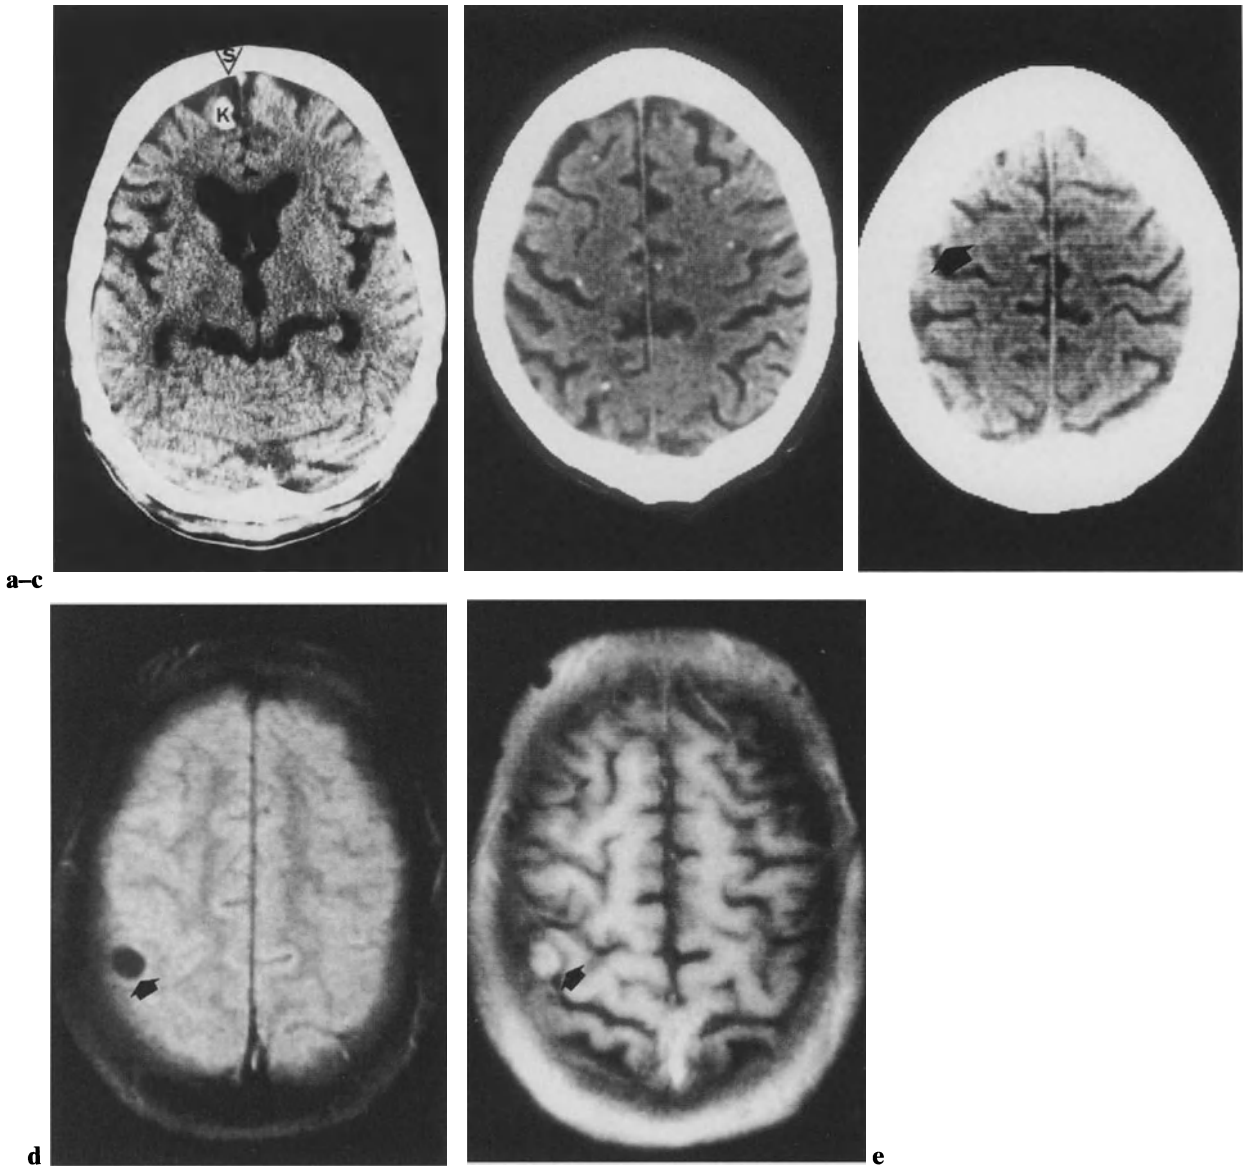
Focal calcifications as an example of the CT and MRI appearances of residual changes. a A patient who had been treated medically for a large frontal toxoplasmotic abscess several months previously showed a coarse calcification (*K*) adjacent to the gyral scar (*S*). b Following disseminated cerebral toxoplasmosis, multiple, small calcified foci can be observed. c A hyperdense calcification can be seen adjacent to the inner
